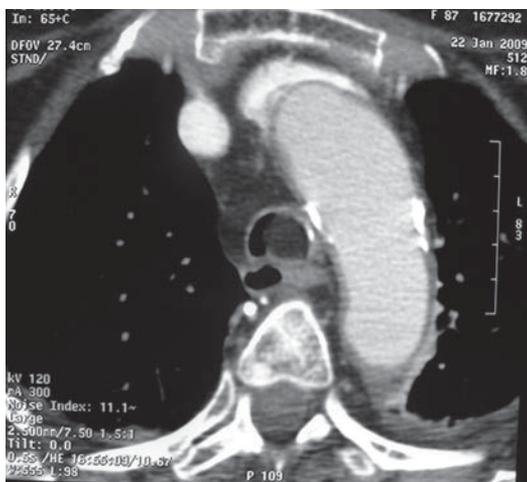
Chest CT scan showing lesion with adipose tissue density in the trachea.
